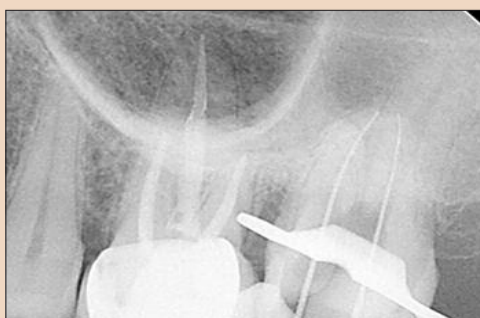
WL radiograph for buccal canals
